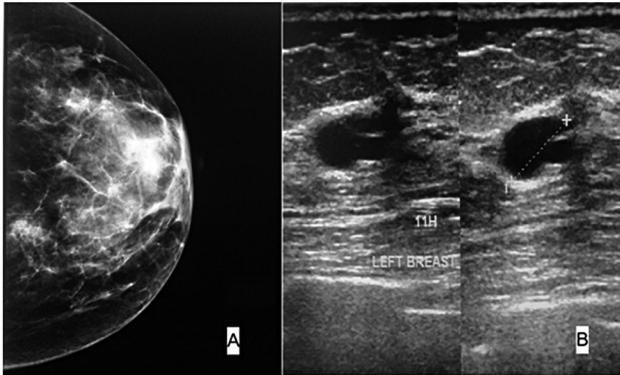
A: Mammography showing a high density irregular mass with calcifications suspicious of malignancy, with no skin thickening. B: Ultrasound scanning of the left breast showing a solid, hypoechoic mass, measuring 6.4 cm in diameter BI-RADS 5 in the 11<sup>th</sup> hour of the left breast.
